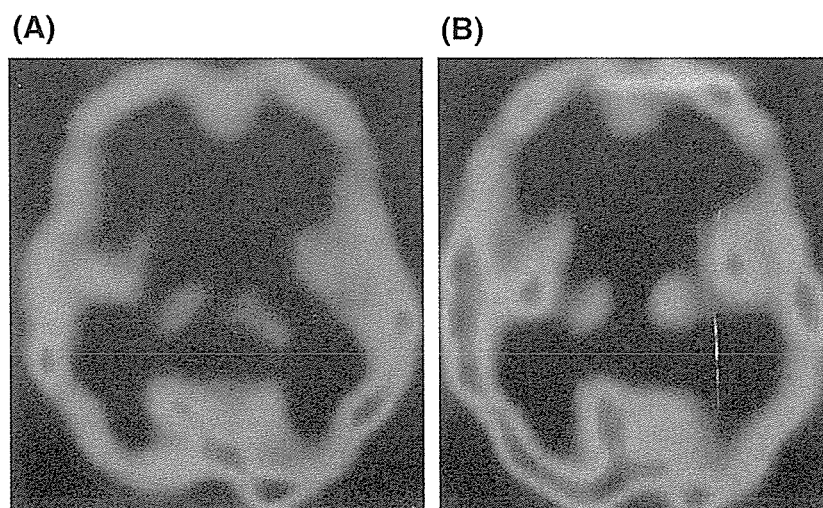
SPECT images. (A) Day 0, (B) Day 130.
